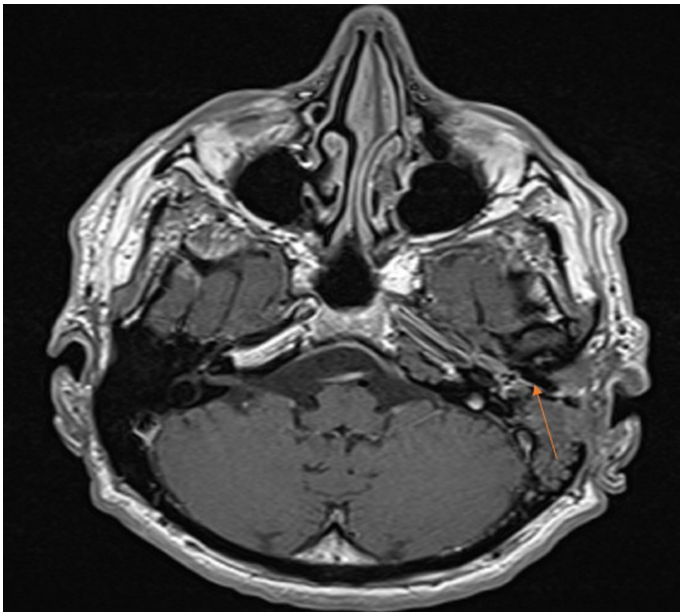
A, B. Axial T1-weighted magnetic resonance images showing post-operative scans of the temporal bones 12 months after surgery (arrows pointing to the left cavum tympani with no signs of tumor recurrence).
